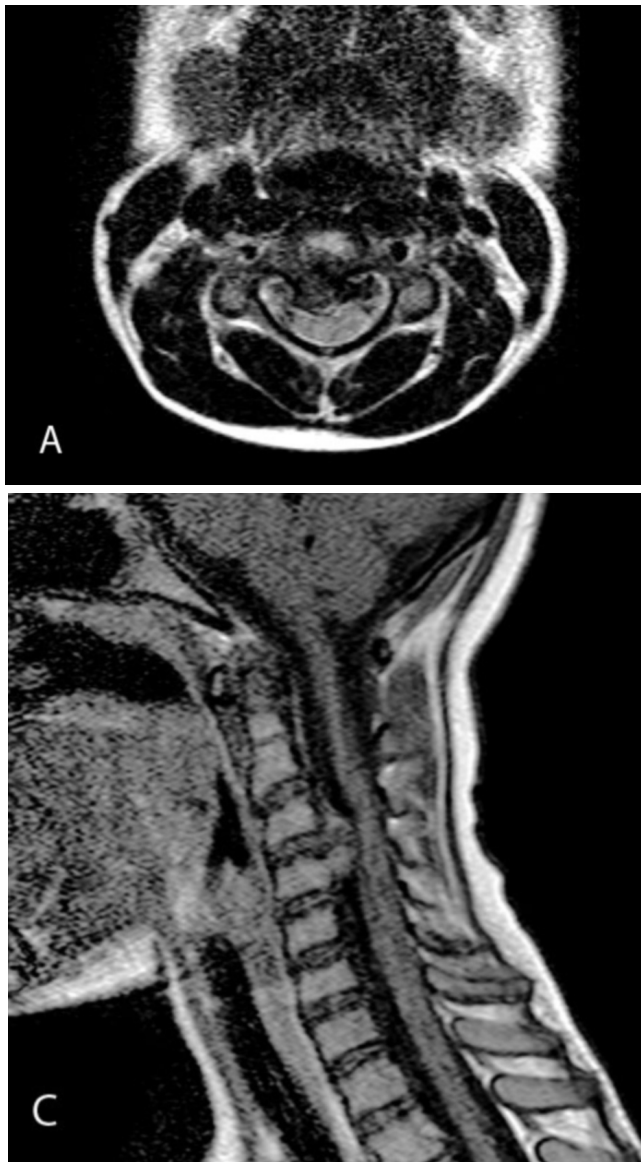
Eight-year-old female with cervical spine osteochondroma. MR images. Axial T2 (4100/100)-weighted (A), sagittal T2 (3500/135)-weighted (B), and sagittal T1 (400/12)-weighted postcontrast (C) images show a circumscribed lesion isointense to bone marrow on all sequences, arising from the C4 posterior vertebral body, with marrow continuity with the parent vertebra. A small, mildly hyperintense cartilage cap is possibly identified on the T2-weighted images. The lesion protrudes into the central canal, resulting in compression and flattening of the anterior spinal cord.
